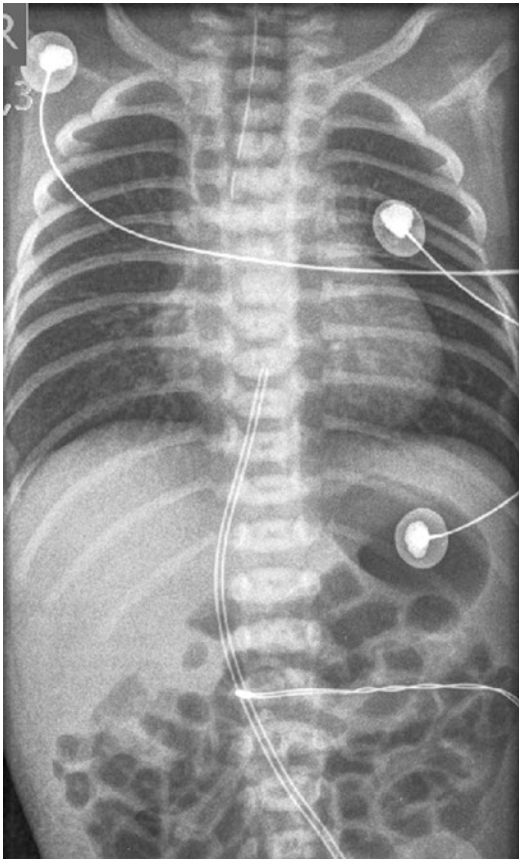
X-ray of a newborn baby with an EA/TEF (type C). The tip of the Replogle tube marks the lowest point of the upper pouch. The TEF allows for gas passing into the gastrointestinal tract
